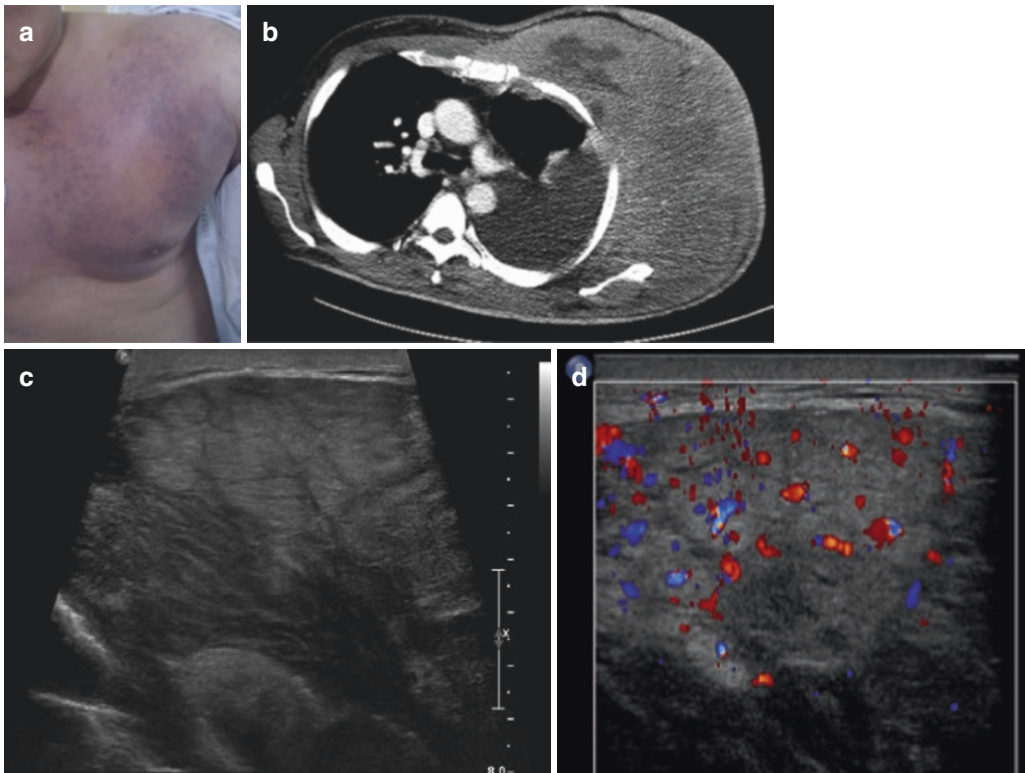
Diffuse large B-cell lymphoma. The patient presents with a rapidly growing chest wall mass and skin color change (a). Contrast-enhanced chest CT (b) shows diffuse soft tissue and skin thickening. The corresponding
